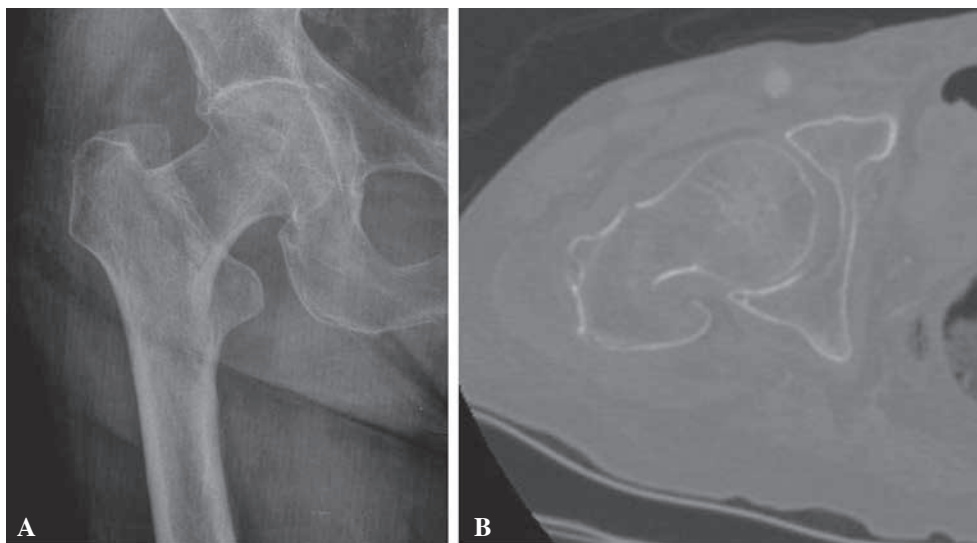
Male patient, aged 83. A : AP X-ray shows a basicervical fracture in the right hip that had occurred after a simple fall. B : Coronal computed tomography (CT) section of fracture.
